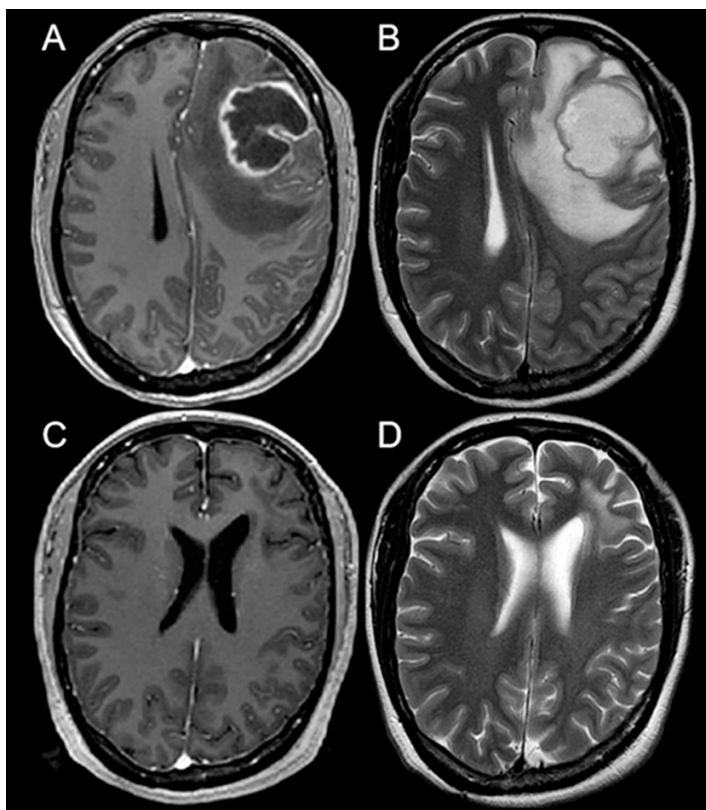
A) Preoperative magnetic resonance imaging (MRI), axial section in FSGPR (3D fast spoiled gradient-echo dual-echo) sequence with contrast, shows a left frontal abscess with significant mass effect, with midline deviation and obliteration of the right ventricle, the wall is irregular with intense contrast uptake. B) Axial image in T2 sequence, frontal perilesional edema and subfalcine herniation are more clearly seen. C) MRI obtained after 19 months of surgery shows complete resolution of the abscess, and ventricular asymmetry due to traction of the anterior portion of the left ventricle due to cicatricial gliosis. D) in the T2 sequence, left frontal subcortical hyperintensity due to gliosis.
